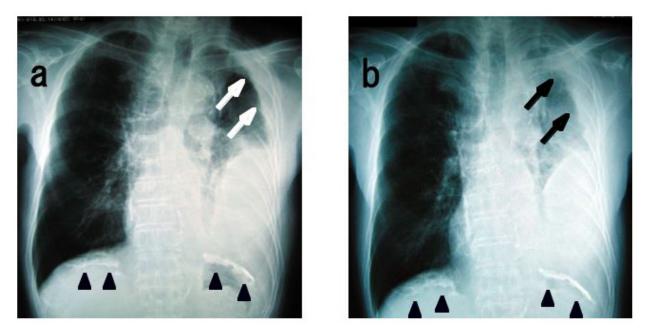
Serial images of chest X-ray. a: A chest X-ray from the first visit shows an opacity with lobulations in the lower left lung and thickened soft tissue density (arrows) along the pleura in the upper lung. There are calcified lines (arrowheads) in the bilateral bases of the lung. *b*: A chest X-ray on admission shows the increased size of the lobulated opacity in the left lung. The upper part of the opacity also has increased thickness along the pleura (arrows) with progressively increasing density in the aerated left lung. Calcified lines (arrowheads) in the bilateral bases of the lung bases of the lung showed no change.
